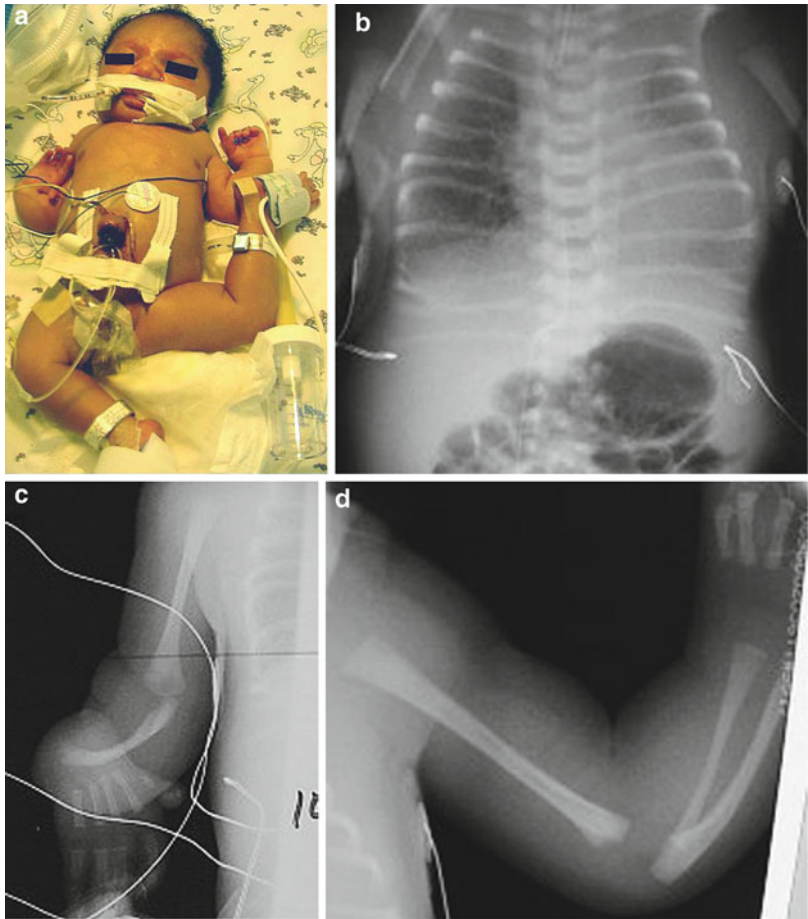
(a, b) A child (a) with VATER association showing club hands and missing thumbs. Radiograph showed absence of the first phalanges and metacarpals and radial aplasia (b)
